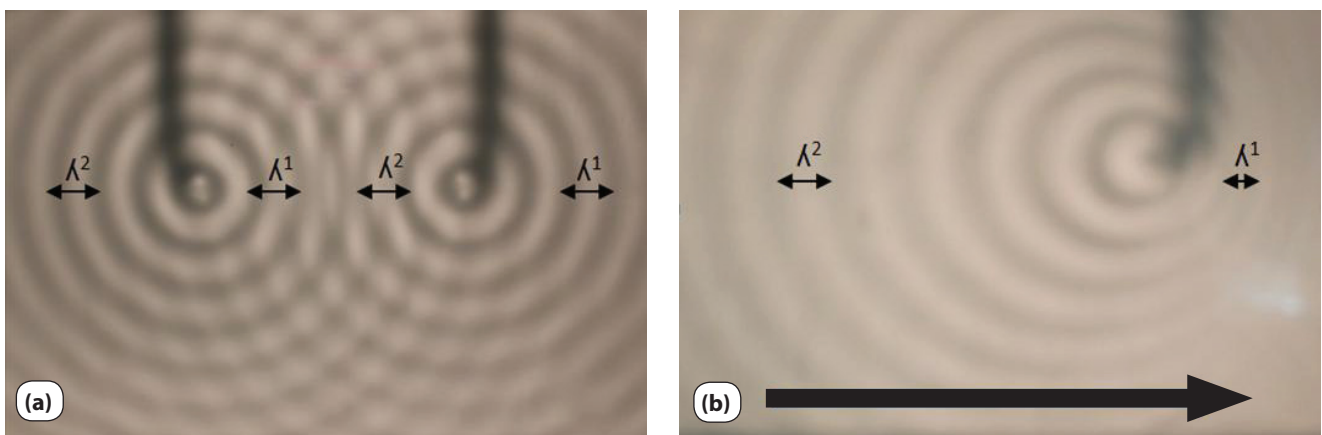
The Doppler Effect: Wavelength: spatial period of a wave (λ): (a) Two stationary sources of acoustic waves: sound pitch (frequency) perceived equal both on the left and on the right sides ($\lambda^1 = \lambda^2$): no Doppler effect; (b) A source of acoustic waves moving from the left (λ^2) to the right (λ^1): Sound pitch (frequency) perceived higher on the right than on the left sides ($\lambda^1 > \lambda^2$).
